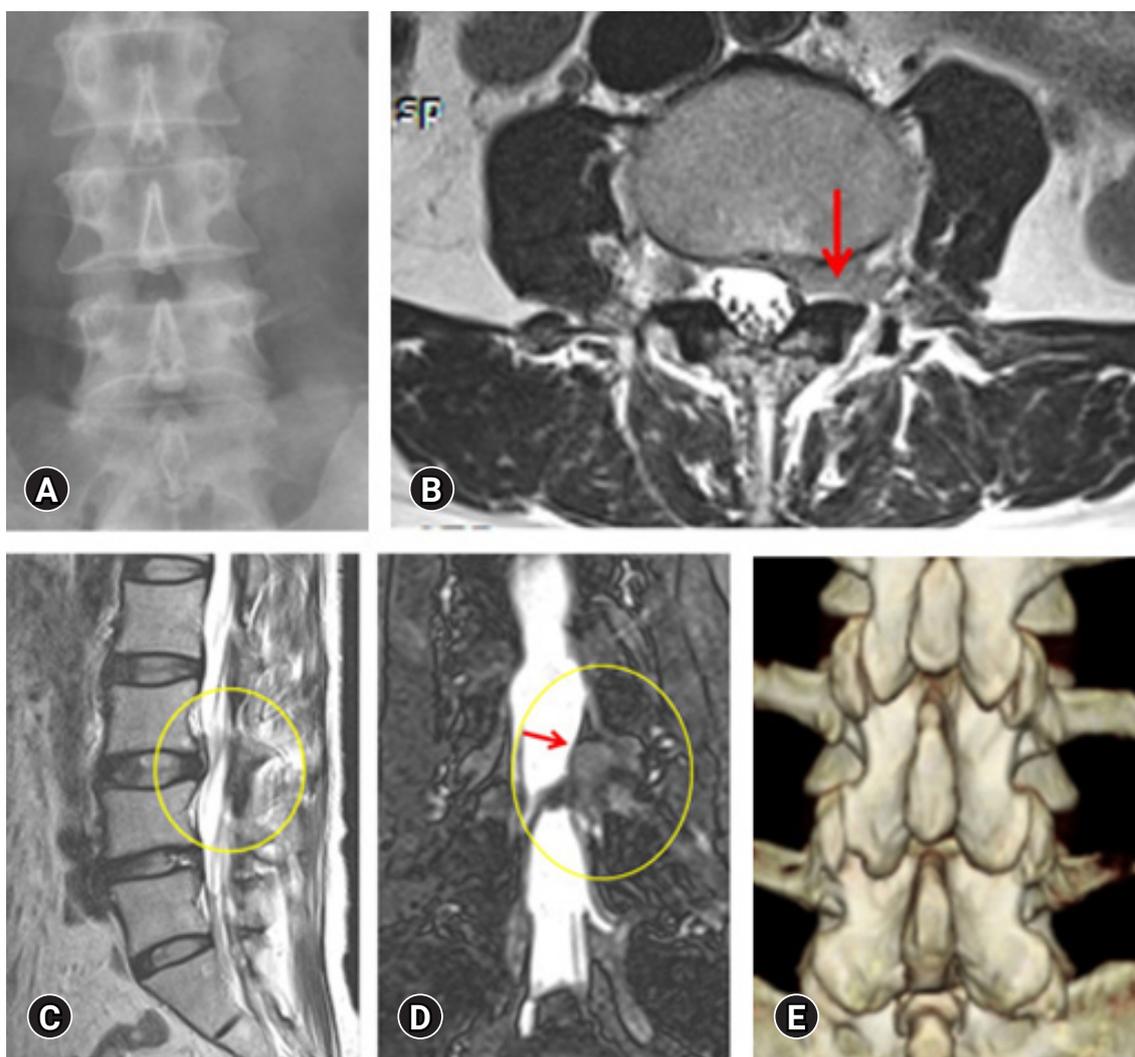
Different preoperative images that helps to localize the exact position of up-migrated disc and plan the exact target point of keyhole. (A) X-Ray, (B) MRI Axial, Red arrow showing migrated disc fragment. (C) MRI Saggital, Yellow circle showing migrated disc fragment (D) Myelogram, Yellow circle and red arrow showing migrated disc fragment (E) 3D CT.
